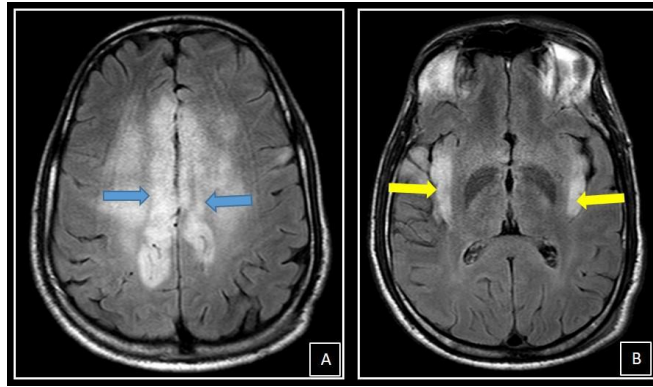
HSV encephalitis A, B: FLAIR axial C: FLAIR coronal D: DWI A, B, C: FLAIR hyperintensity noted in both the cingulate gyri (blue arrows) and the insular cortices (yellow arrows).
